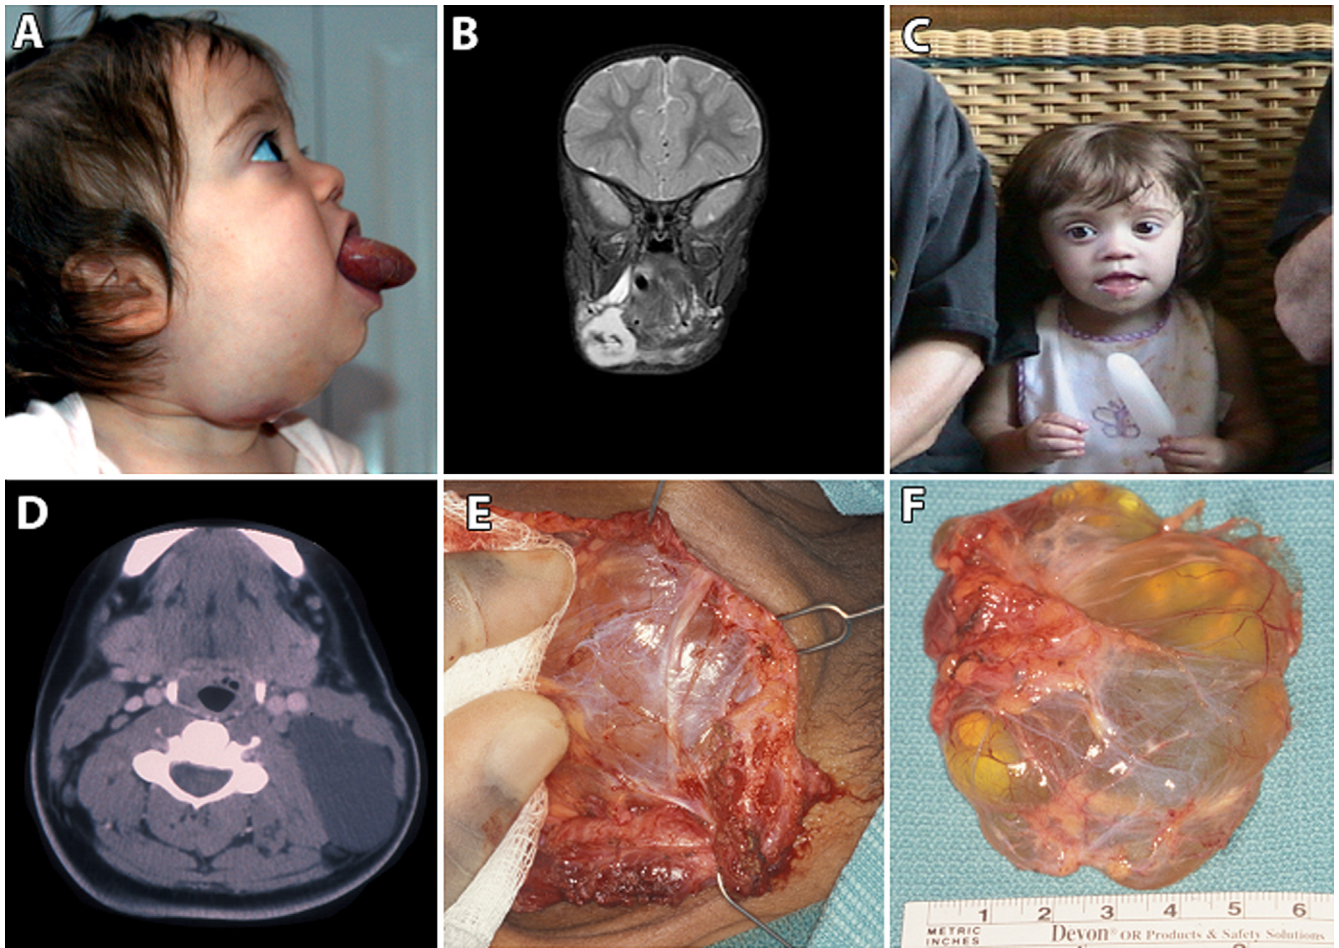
(A) A photograph and (B) an MRI of a 2-year-old girl with a large cervical–facial predominantly microcystic lymphatic malformation. The lymphatic malformation occupies the right submandibular gland, floor of mouth, and tongue. (C) The same patient after surgical excision of the tongue and neck lymphatic malformation. (D) An MRI of a 15-year-old girl with a left neck focal macrocystic lymphatic malformation. (E and F) Appearance of the macrocystic lymphatic malformation intraoperatively and after excision. Notice the large cystic cavities filled with a yellow clear fluid. (Color version of figure is available online.)
